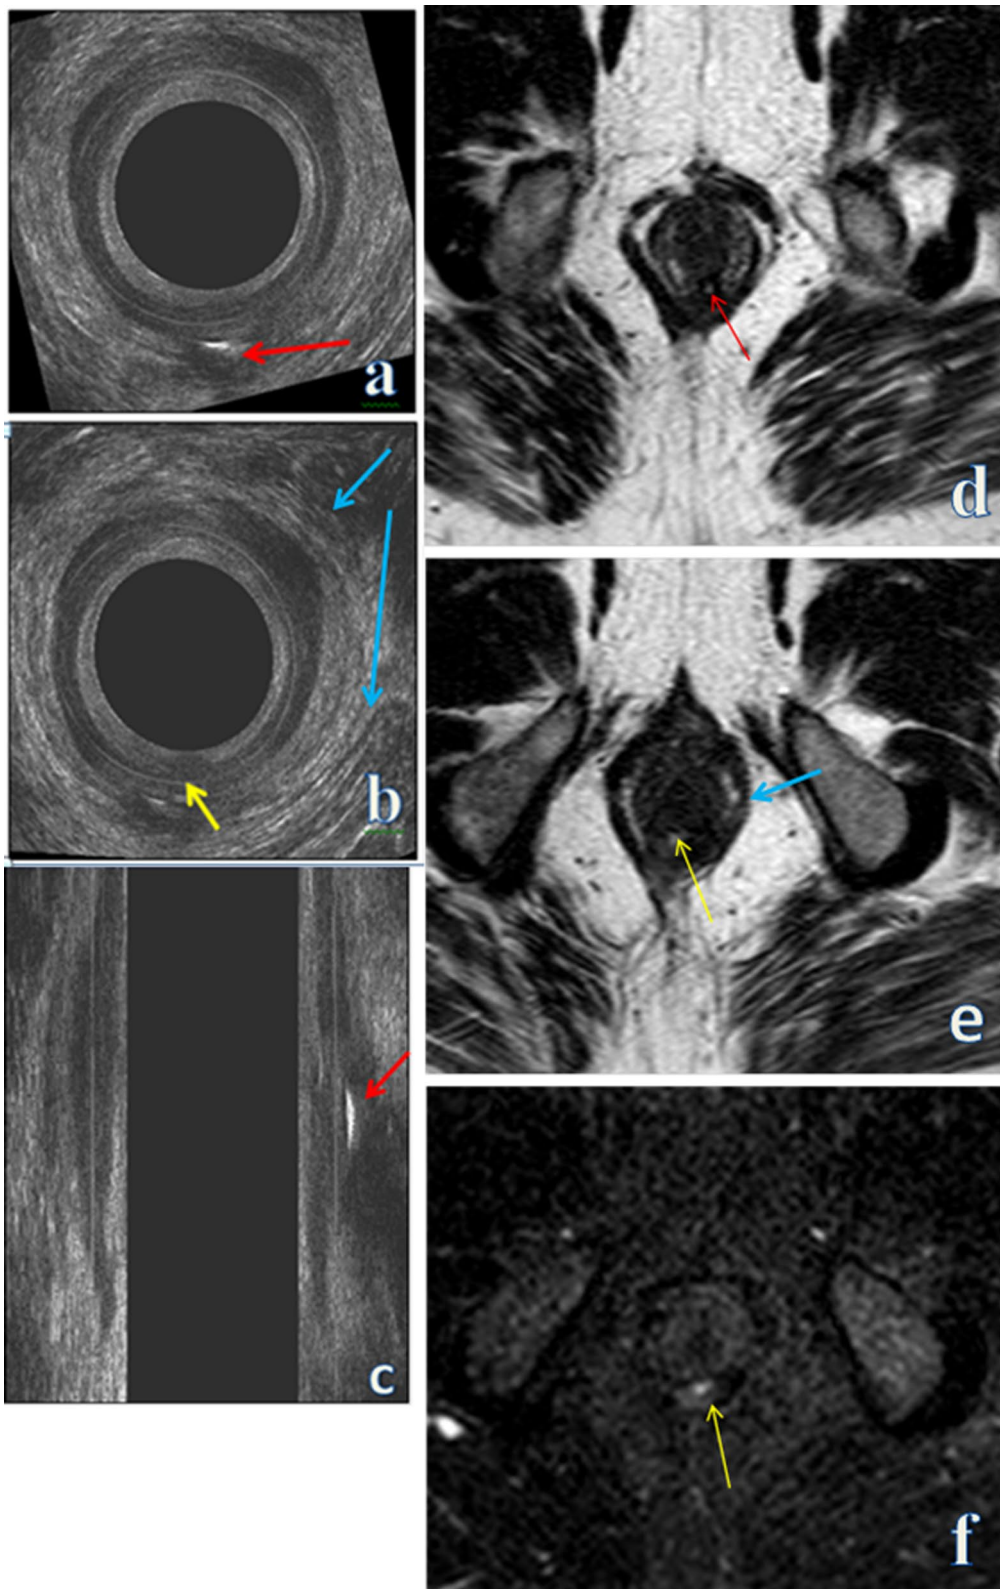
a, b axial and c sagittal reconstructed EAUS images show intersphincteric hypoechoic fistulous track (red arrows) showing internal echogenic air loculi and abutting IAS at 6 O'clock (yellow arrow). d, e axial T2 WI and f axial STIR WI MRI images show fluid filled intersphincteric fistula, eliciting high T2/STIR SI (red arrow), abutting IAS at 6 O'clock (yellow arrows). Blue arrows refer to EAS in b EAUS and e MRI images
